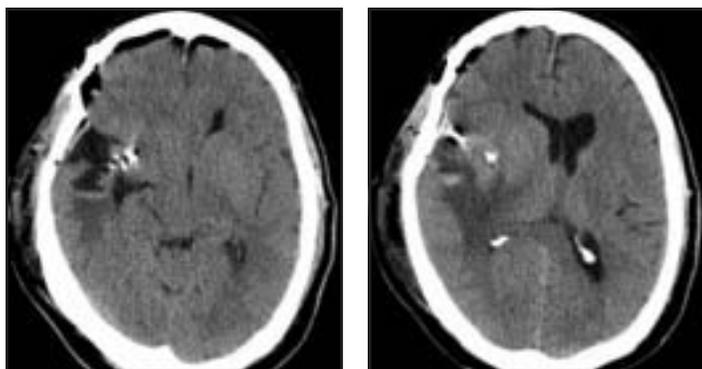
Postoperative head CT shows complete resection of the aneurysm without hemorrhage.
